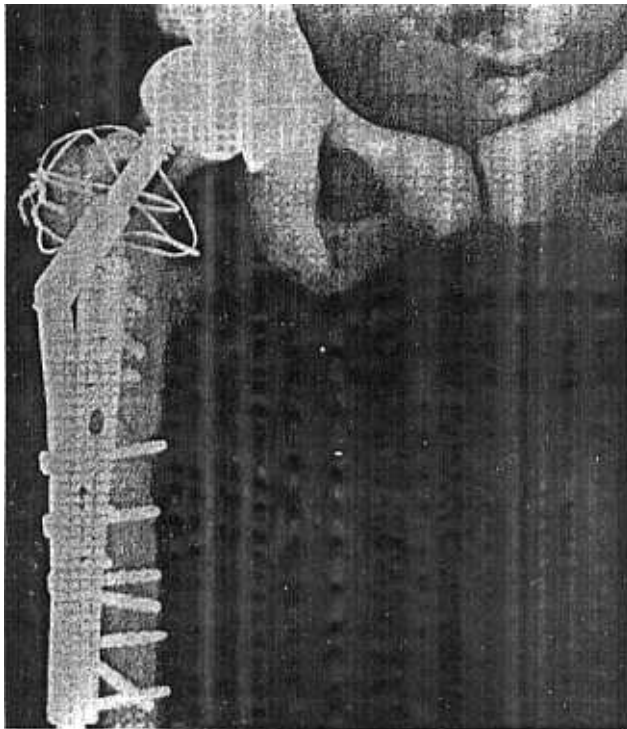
Radiograph after insertion of a resurfacing arthroplasty.
